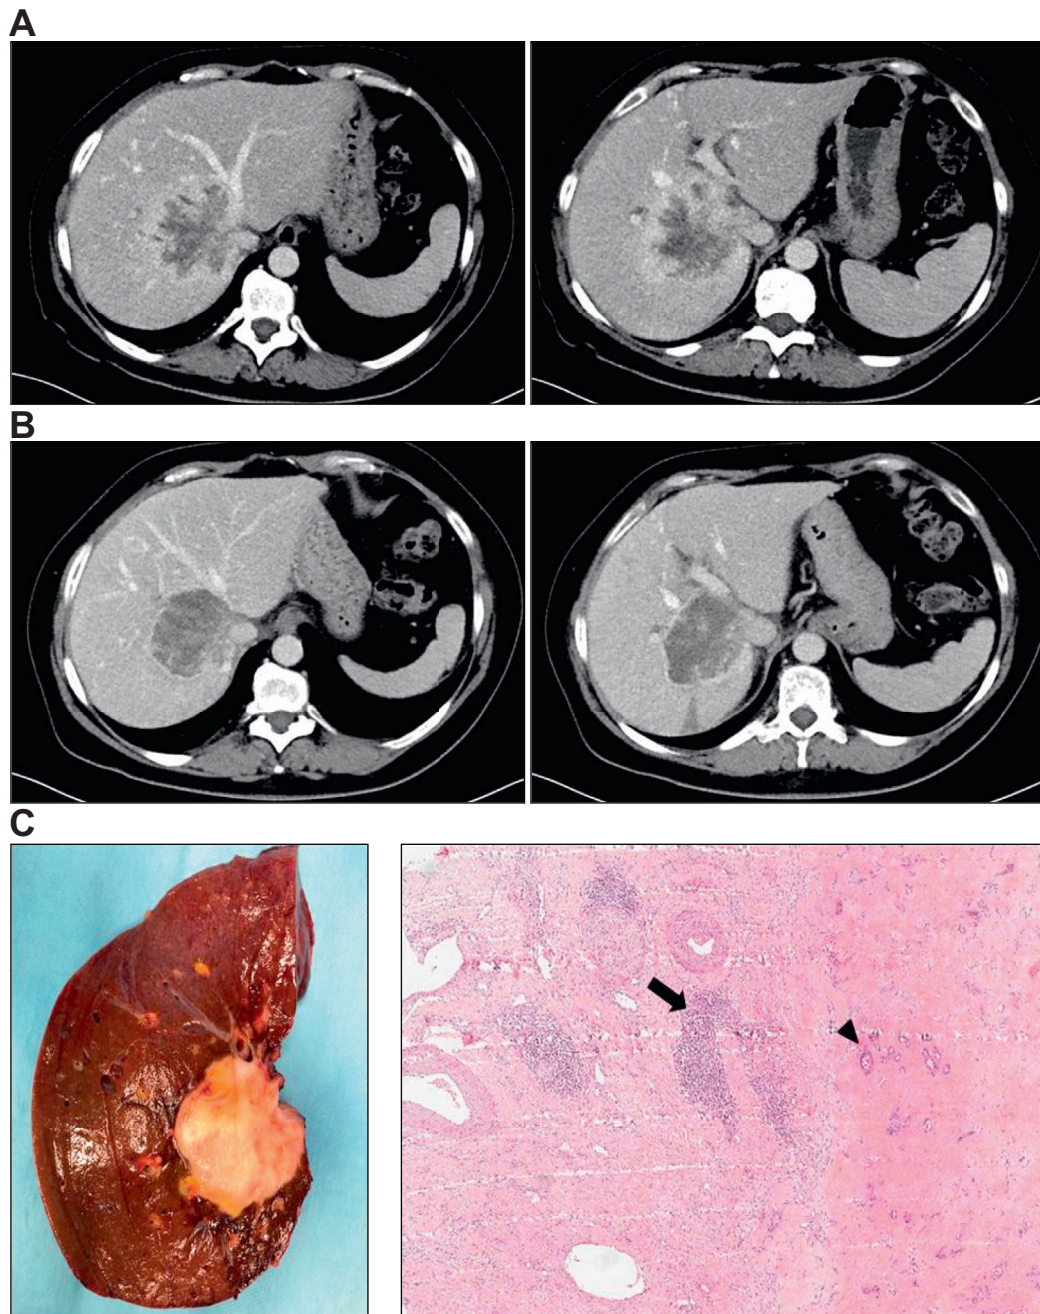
Liver transplantation after sustained response to neoadjuvant combined treatment. Large, single iCCA in a 58-year-old woman with preserved liver function and metabolic syndrome. (A) Large iCCA: at diagnosis the CT scan shows tumour involving the hepato-caval confluence, with invasion of the right hepatic vein, infiltration of the inferior vena cava together with the middle and left hepatic vein common trunk. The tumour is adherent to portal bifurcation and biliary confluence. The patient underwent first-line chemotherapy with gemcitabin and cisplatin (4 courses) followed by Y^{90} radioembolisation. (B) Sustained tissue response after neoadjuvant treatment: partial response was observed with extensive necrosis of the liver lesion, remaining stable in size for 6 months. After 4 additional months, liver transplantation was performed under a prospective protocol using a graft of marginal quality. The patient is alive and free of recurrence 2 years after transplant. (C) In the explanted liver, extensive fibrosis of 70% of the tumour, necrosis and inflammatory infiltrate (arrow) were detected with residual tumour nests in its context (arrowhead), focally infiltrating the vena cava and the right hepatic vein. Middle and left hepatic veins were encased but not invaded. Portal vein thrombosis was not neoplastic.
